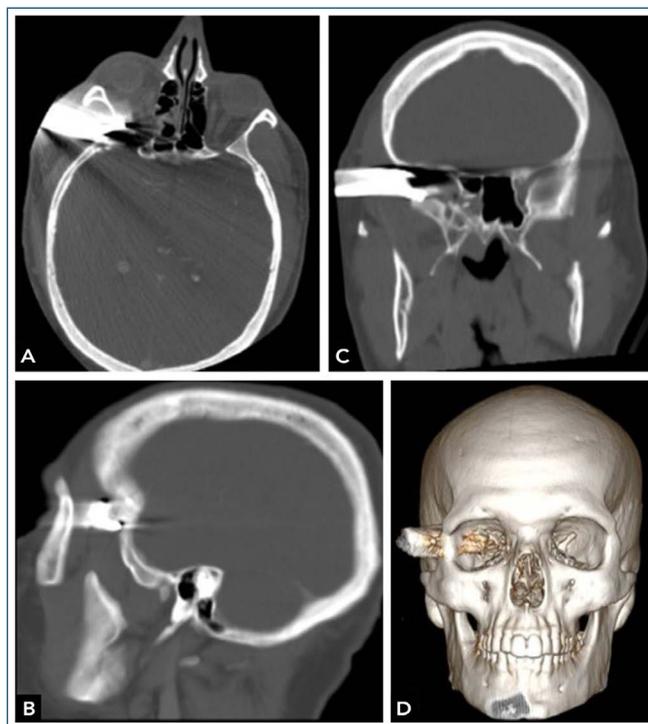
Bone window computed tomography image in the axial (A), sagittal (B), coronal (C) and volume rendered (D) planes showing a metallic foreign body lodged in the skull on the right, causing a fracture of the orbital face of the zygomatic and greater wing of the sphenoid, with the tip in the orbit.
